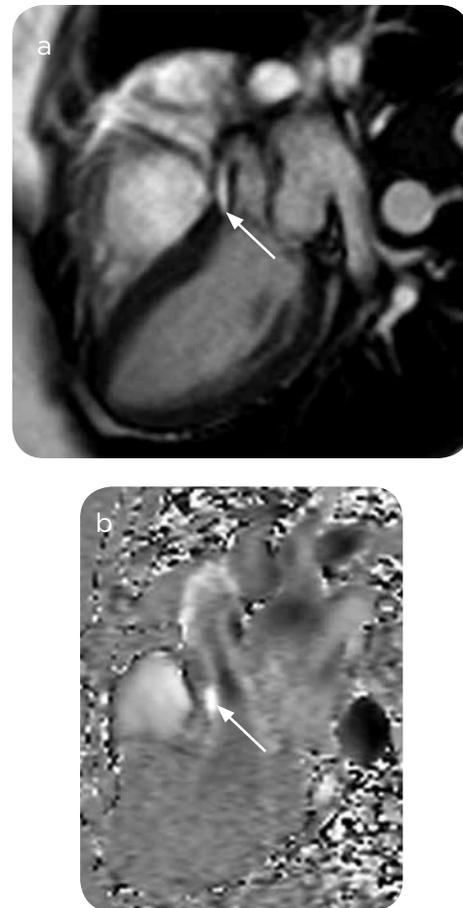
25-year-old female patient with a membrane in the LVOT. Cardiac MRI, SSFP cinema sequences, long axis projection of three chambers (a) and phase contrast sequence in the plane of the outflow tract of the left ventricle (b), where the membrane is seen extending from the basal septum to the base of the anterior valve of the Mitral valve (arrow in a) which causes acceleration of the flow (arrow in b), in systole in the outflow tract.
